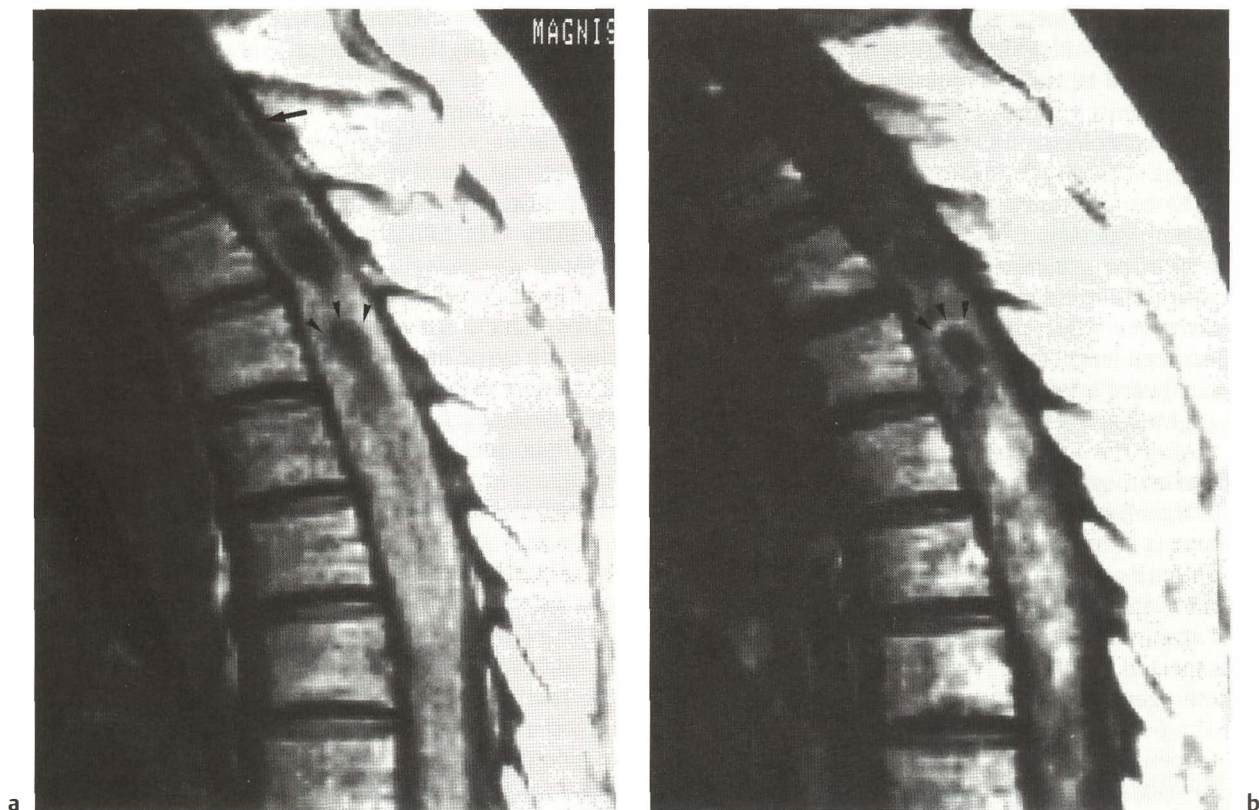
Grade II thoracic astrocytoma (case 83; same case as in Fig. 76). a Sagittal precontrast T1-weighted image and b sagittal contrast-enhanced T1-weighted image, showing partial and heterogeneous contrast enhancement of the tumor. There is an intratumoral cyst with an enhancing wall (arrowheads). Note the associated hydrosyringomyelic cyst (arrow)
